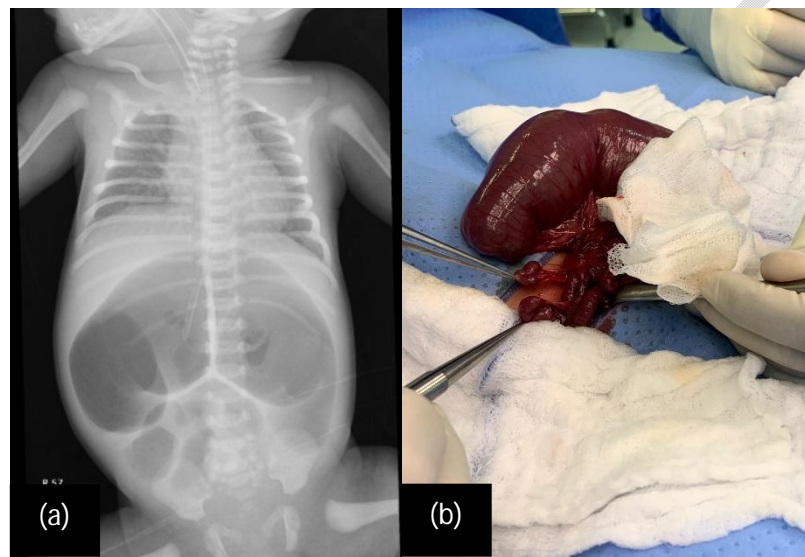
(a): Abdominal X-ray done pre-operatively with dilated bowel loops with the tip of orogastric tube in right hypochondrium; (b): Intra-operative findings showing multiple atresia
